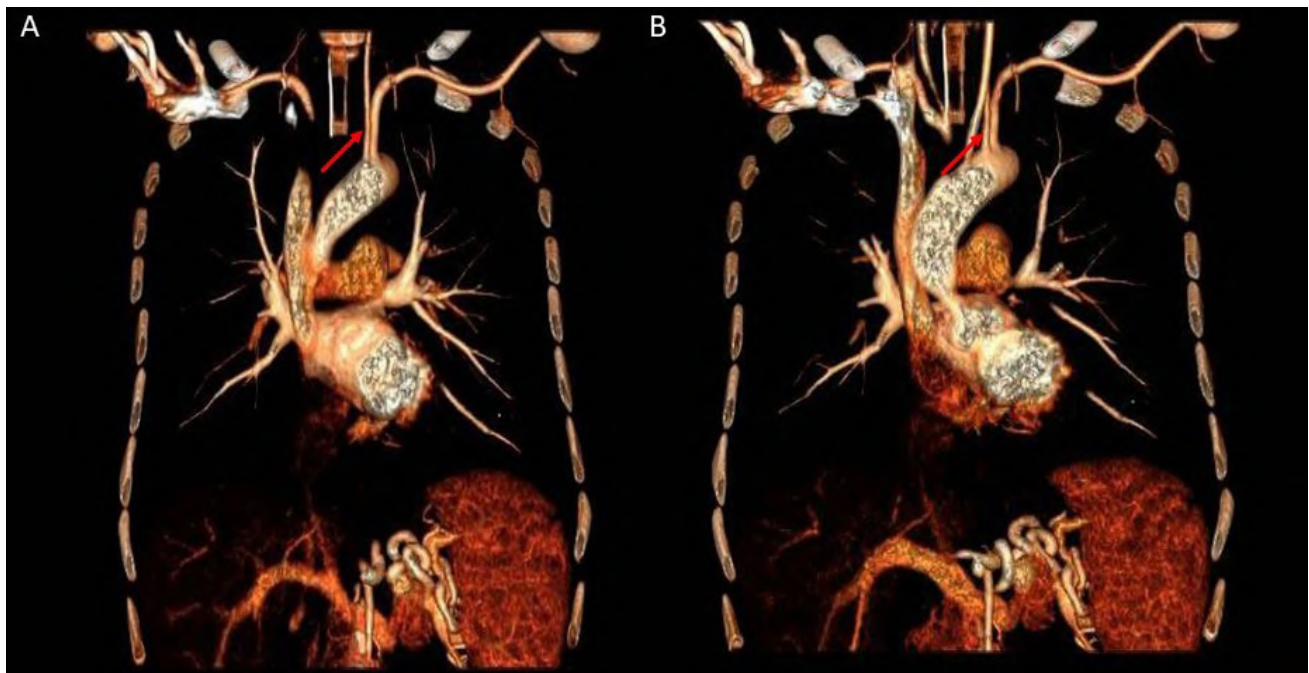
Coronal CT vascular reconstruction showing aberrant origin of left vertebral artery (red arrow) from aortic arch (A and B, different coronal views).
